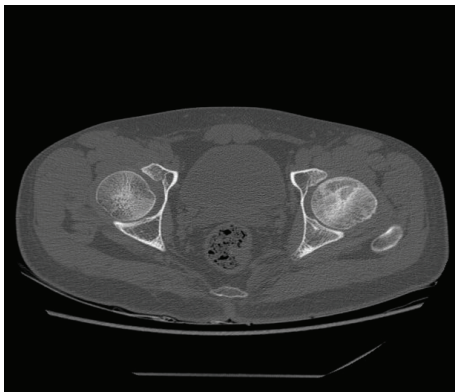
CT picture of normal position of pelvis (before surgery).
